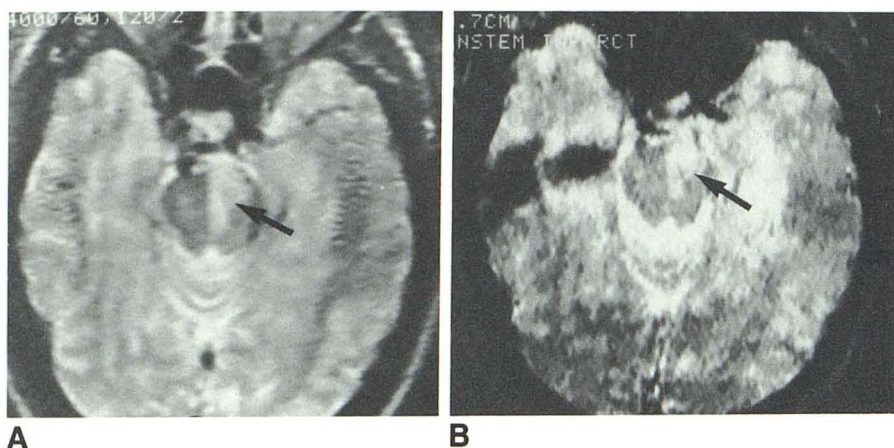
Patient with nonhemorrhagic pontine infarct. A, T2-weighted SE image (TE = 120 msec) shows hyperintense infarct (arrow). B, T2-weighted PS image (TE = 50 msec) again shows hyperintense lesion (arrow). There is no evidence of any magnetic susceptibility effect within or around the infarct.
